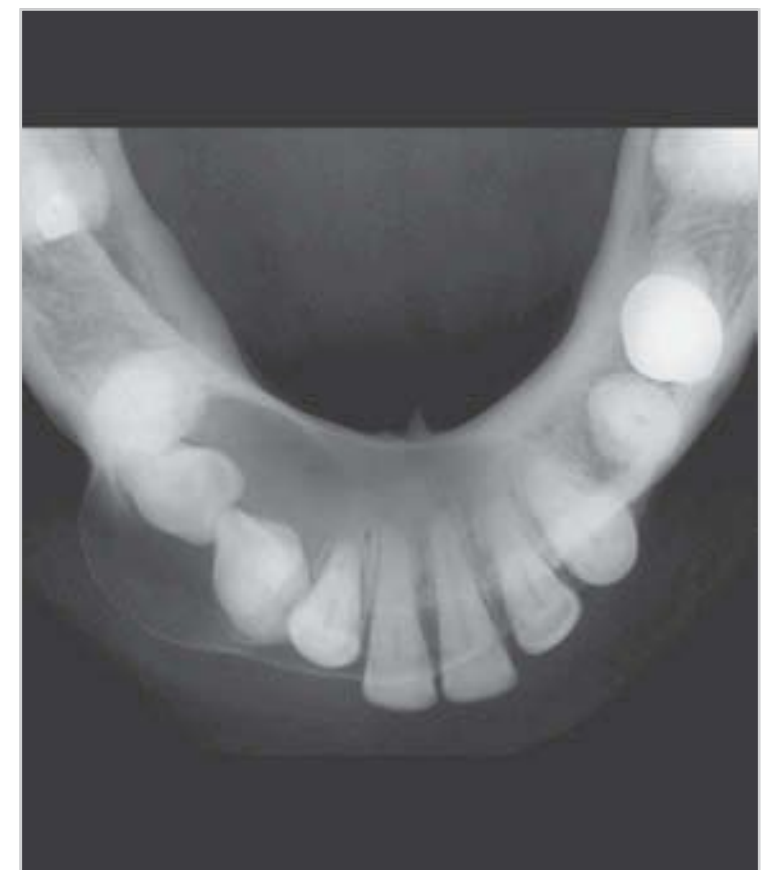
Occlusal radiograph of the floor of the mouth revealed a sialolith in the duct of the submandibular gland.
